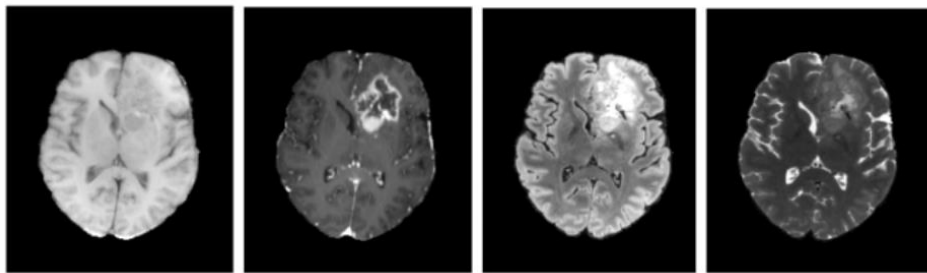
Comparison of T1-weighted, T1-Gd, FLAIR and T2-weighted MRI scans
